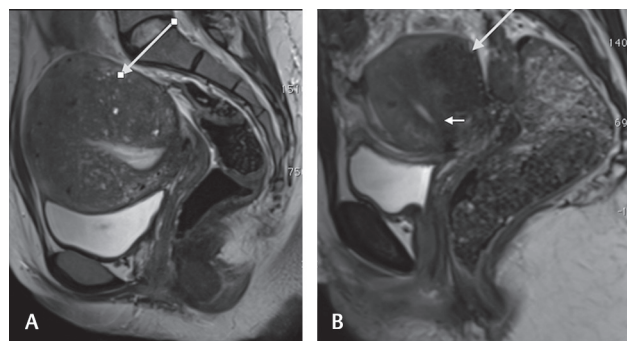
(A, B) T2W sag images (A) showing widening of the junctional zone with diffuse adenomyosis (arrow) and in panel (B) there is a deposit in the posterior serosal surface of the uterus (arrow) with normal thickness of the junctional zone (short arrow). T2W, T2-weighted.
